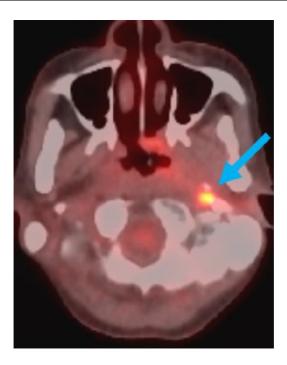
Axial PET-CT shows hypermetabolic activity within the left posterior nasopharynx and Eustachian tube (arrow).
